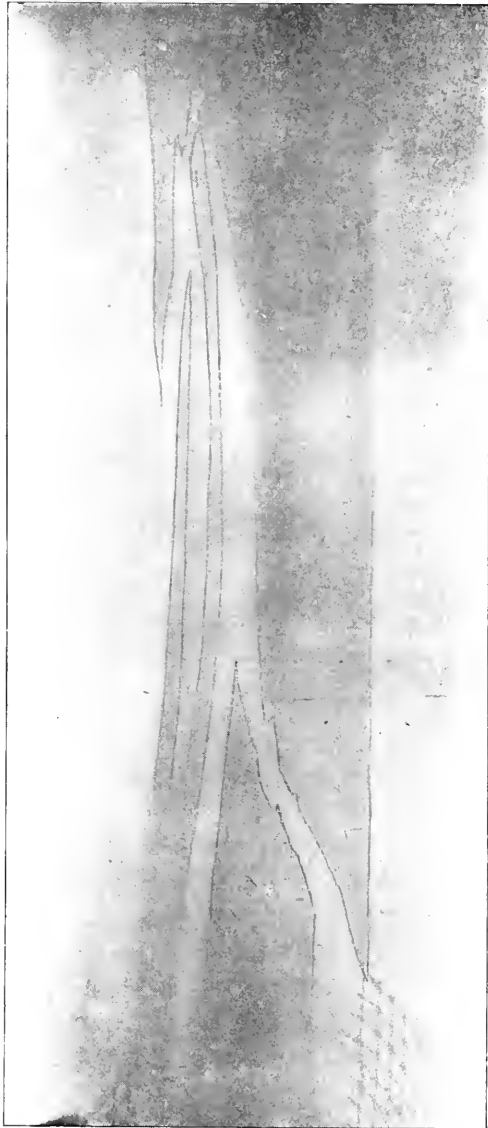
Radiograph of the bones of the leg treated by ambulatory dressing; patient standing.
